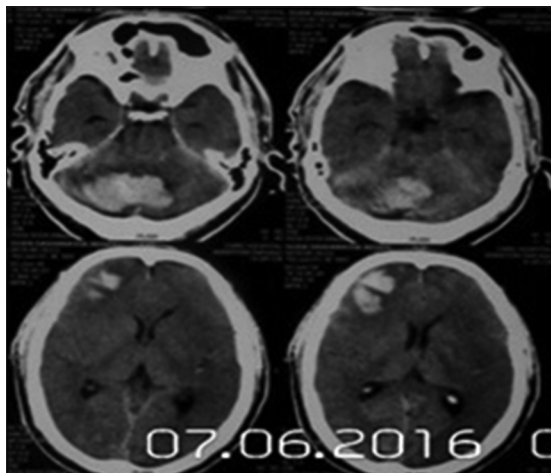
Computed tomography scan brain of 69-year-old patient showing left middle cerebral artery territory infarct with postthrombolysis hemorrhage in bilateral cerebellum and right frontal area
